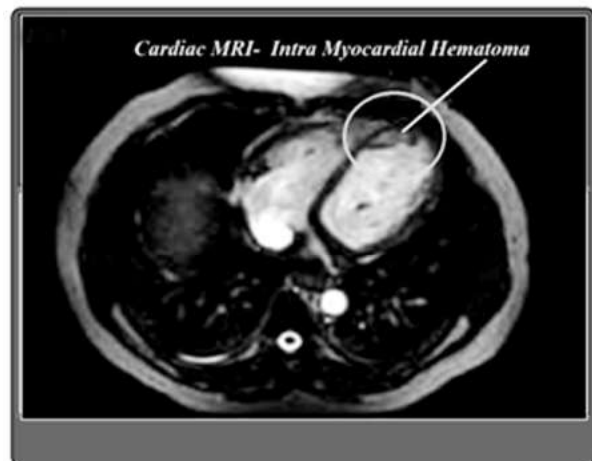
Cardiac MRI- IMH.
